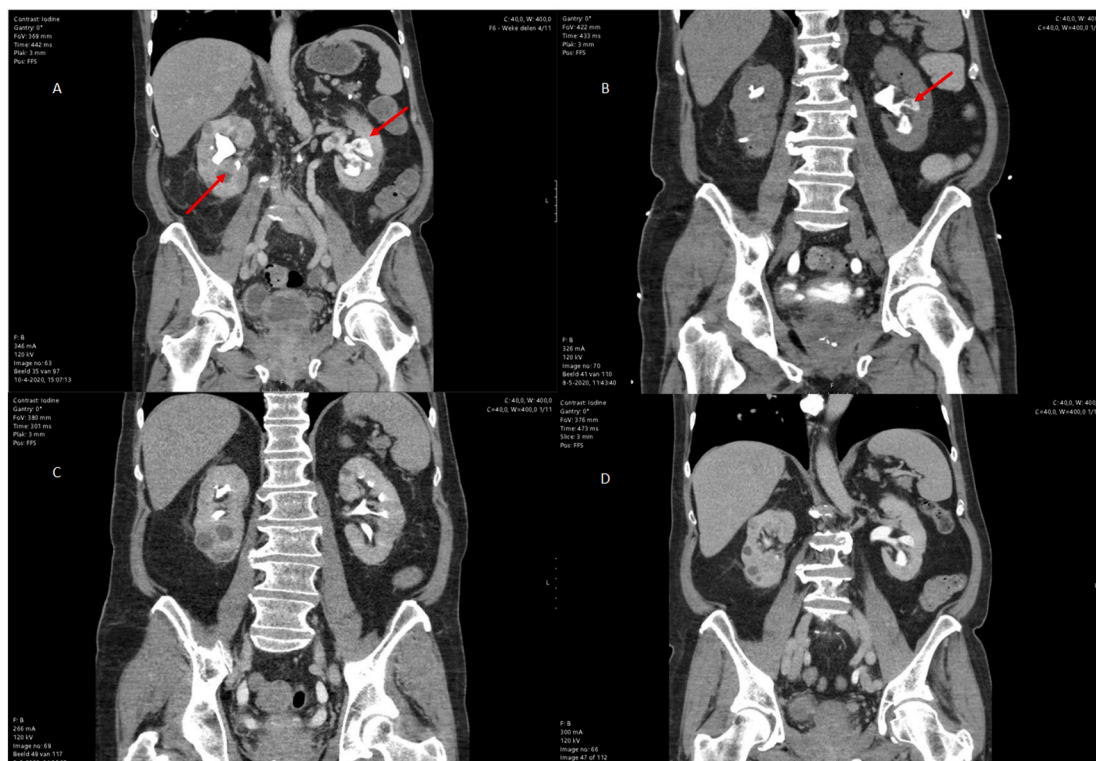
Follow-up of CT-IVP throughout treatment course showing gradual decrease of renal fungal balls. A: Upon presentation showing bilateral hydronephrosis with filling defects in renal pelvises and calices. B: One week after starting anidulafungin irrigation showing improvement but some fungal balls remaining. C: Seven weeks after initial irrigation treatment no fungal balls were remaining. D: Eight weeks after last CT-IVP no recurrence was seen.
